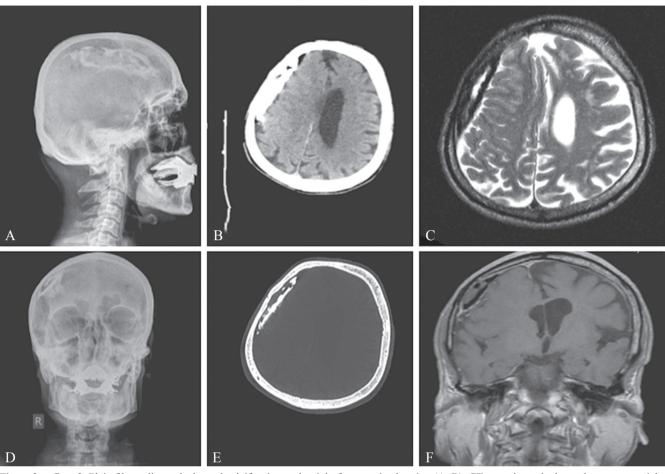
Case 2. Plain film radiograph showed calcification at the right frontoparietal region (A, B). CT scan showed a hyperdense extra-axial mass (C, D). Brain MRI showed that the lesion was isointense on T1 and hyperintense T2 weighted images (E, F).
